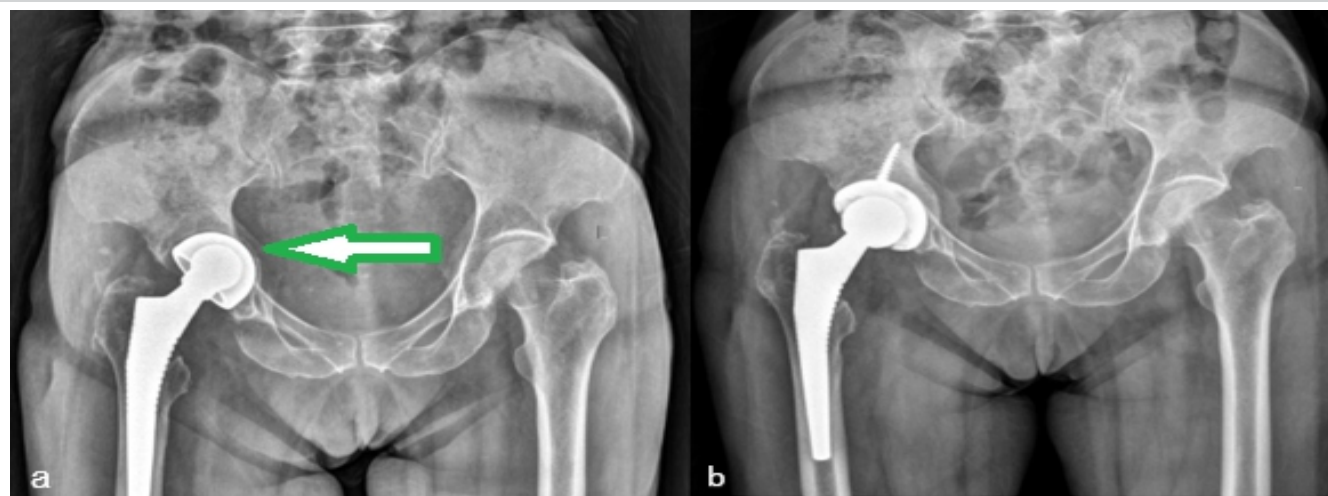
(a) Case 2 infected hemiarthroplasty with protrusion acetabula, (b) 3-year follow-up radiograph after acetabular revision.
